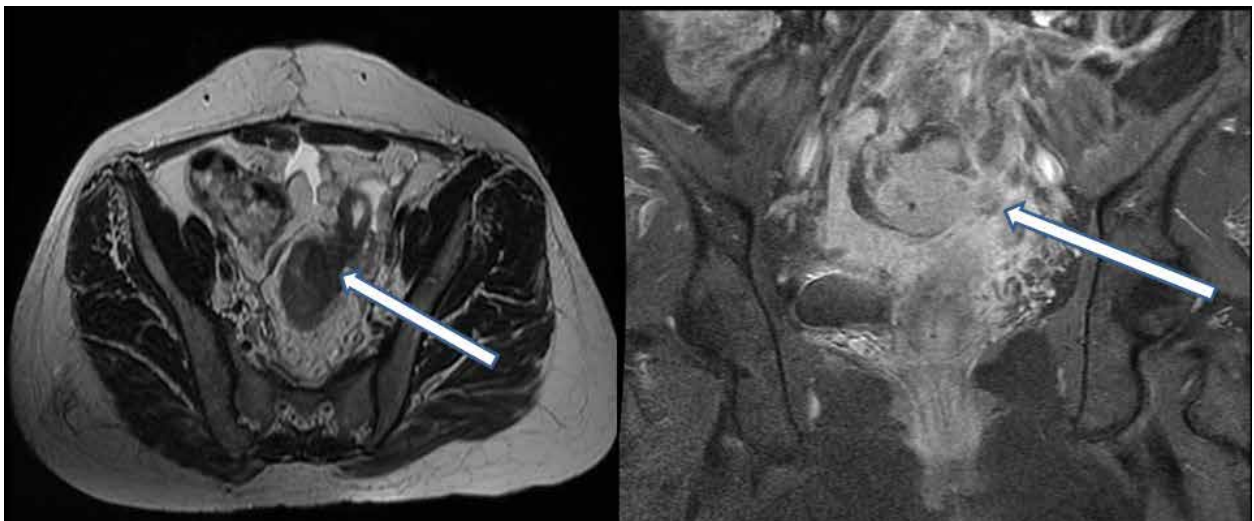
MRI imaging: Mass lesion T4b, which is thought to have invaded the uterus, starting from the rectosigmoid region and extending to the middle part of the rectum associated with the right lateral uterus.
